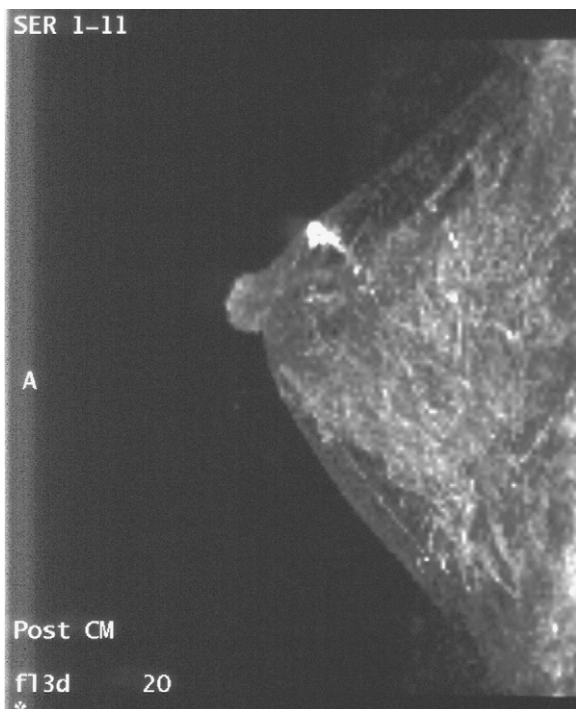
Invasive ductal carcinoma in a 39-year-old woman. Not-palpable. Dynamic-contrast-enhancement-MRM (DCE-MRM), sagittal scan, MIP of early post-contrast phase. Linear ductal enhancement in the same area of microcalcifications at X-ray mammography (not shown). An evident washout was absent in the delayed phase of DCE-MRM (not shown).
